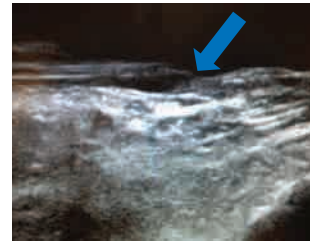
Ultrasound of the foot demonstrating the torn anterior tibial tendon (blue arrow)
